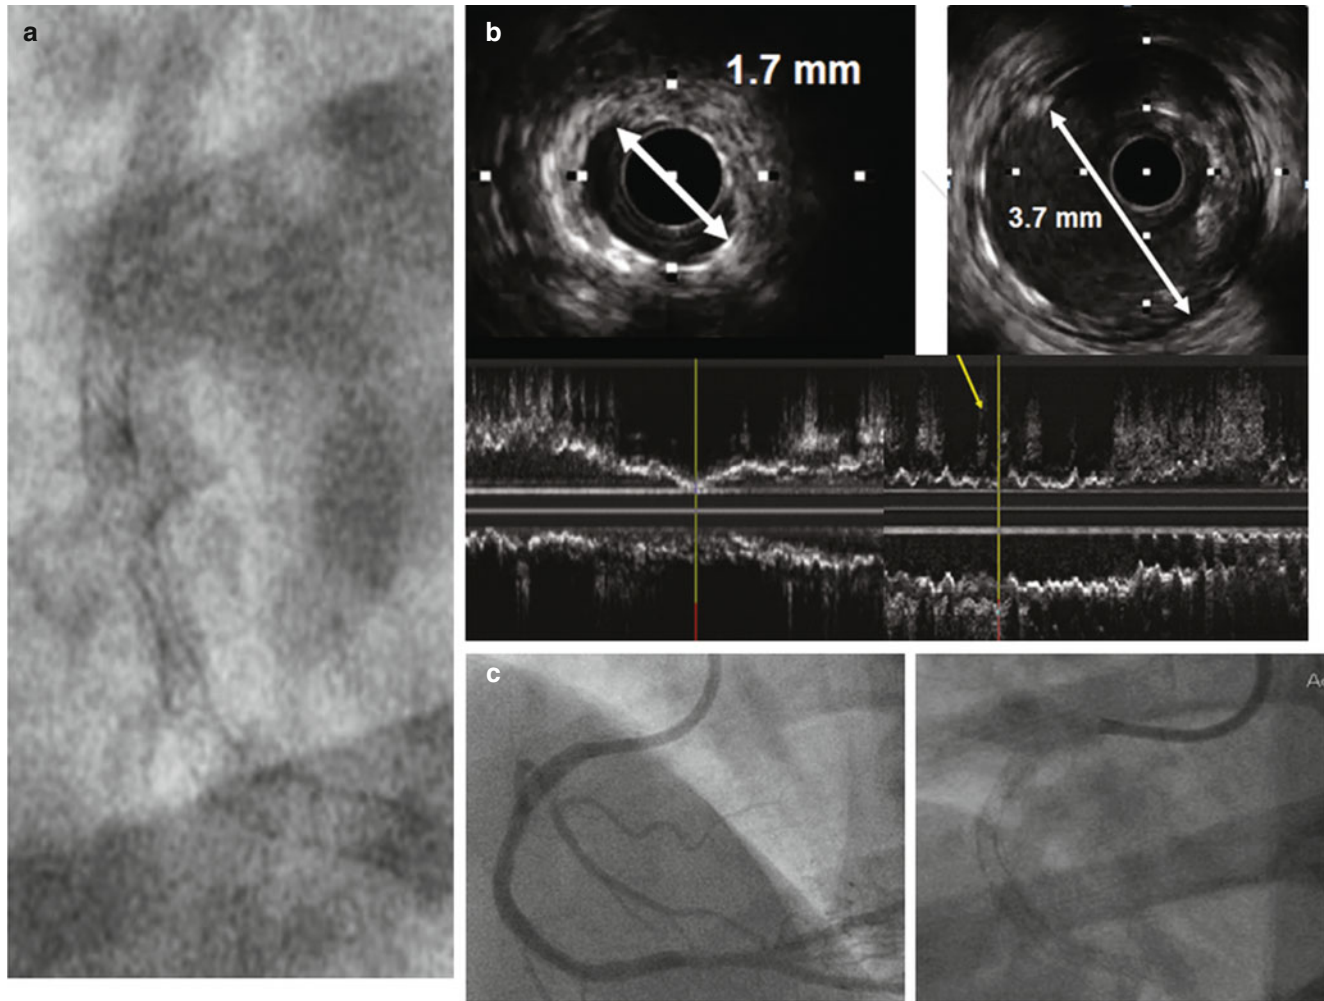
New deployed underexpanded stent. Fluoroscopy revealed underexpanded stent in distal RCA after multiple attempts at dilatation with noncompliant balloon (a). Intravascular ultrasound showed underexpanded stents in an area of severe underlying concentric
